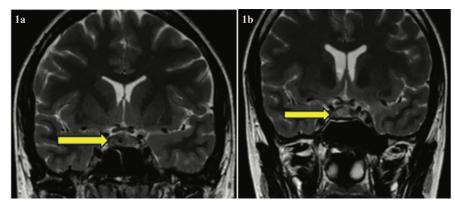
a. MRI conducted pre-operatively. The arrow is pointing at a macroadenoma of the pituitary gland measuring 17 x 11 x 12 mm in large diameter with slight T2 hyperintensity, comprising a non-vascularised central zone of T1 and T2 hyposignal measuring 3 mm.
